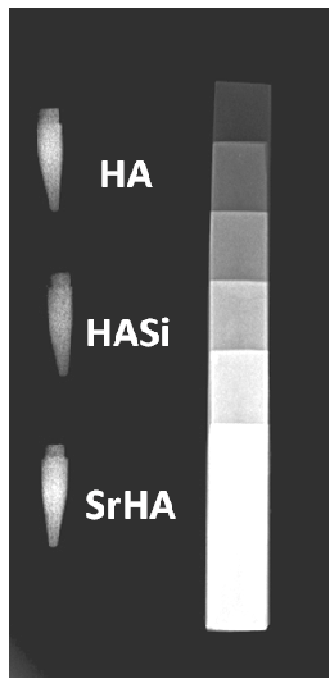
Radiopacity evaluation: Radiograph depicts the radiopacity of HA, HASi and SrHA micro-granular scaffolds in comparison to aluminium wedge.
